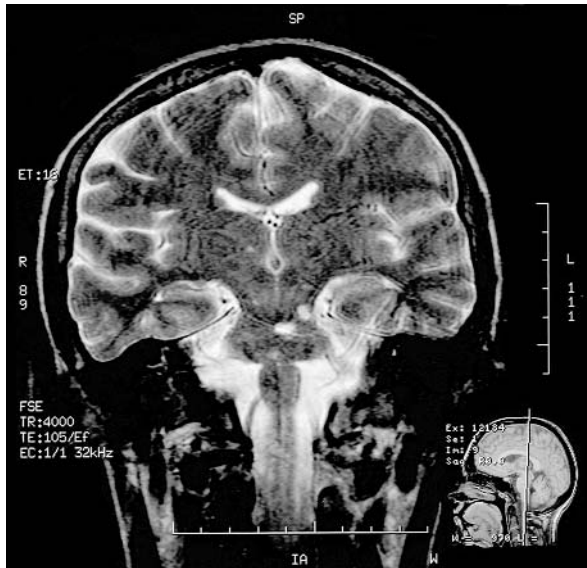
MRI scan confirmed the presence of the ischemic foci previously seen in the CT scan
